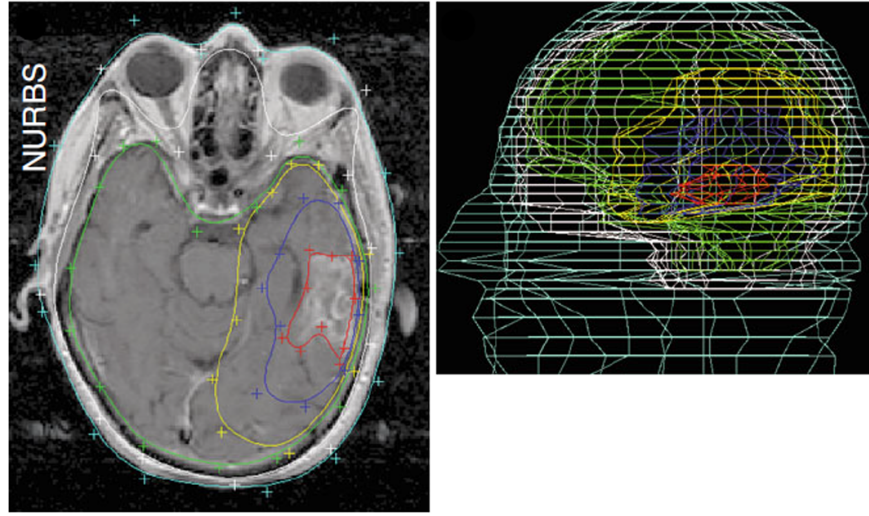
Left: control points indicated by plus signs guide the placement of the spline in the NURBS model, which is overlaid on an MR image. Right: wire-frame rendering of the NURBS model shows the outer boundaries of skin (cyan), skull (white), brain (green), CTV (yellow), edema (blue), and GTV (red) [54].
